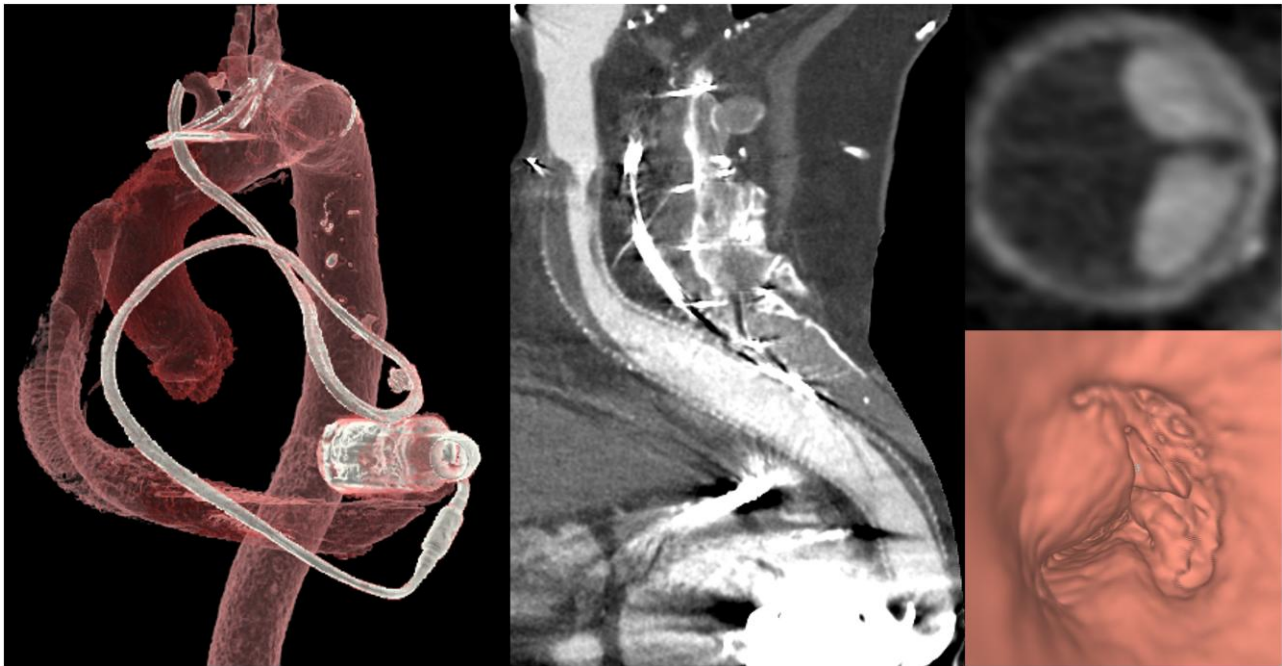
Representative case: a 75-year-old male with end-stage ischaemic cardiomyopathy who underwent placement of a LVAD (Jarvik 2000). He was admitted to the hospital because of repeated Jarvik alarms. CTA of the chest showed an eccentric thrombus causing a severe stenosis at the distal portion of the outflow cannula, subsequently treated by the placement of Optimed Sinus-XL 6F 16 × 120 mm stent.
